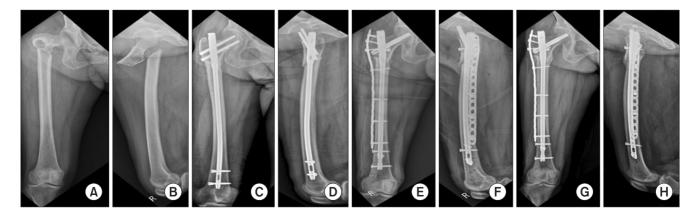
Preoperative anteroposterior (A) and lateral (B) radiographs of a 72-year-old female patient, showing a subtrochanteric atypical femoral fracture by slip down. Immediate postoperative anteroposterior (C) and lateral (D) radiographs showing the fracture fixed with antegrade femoral nails with two distal angular stable locking system screws. Nonunion was diagnosed at 9 months after operation. Immediate postoperative anteroposterior (E) and lateral (F) radiographs showing reoperation of exchange nailing with plate augmentation was performed. Follow-up anteroposterior (G) and lateral (H) radiographs at 6 months after reoperation show bone union was obtained.
